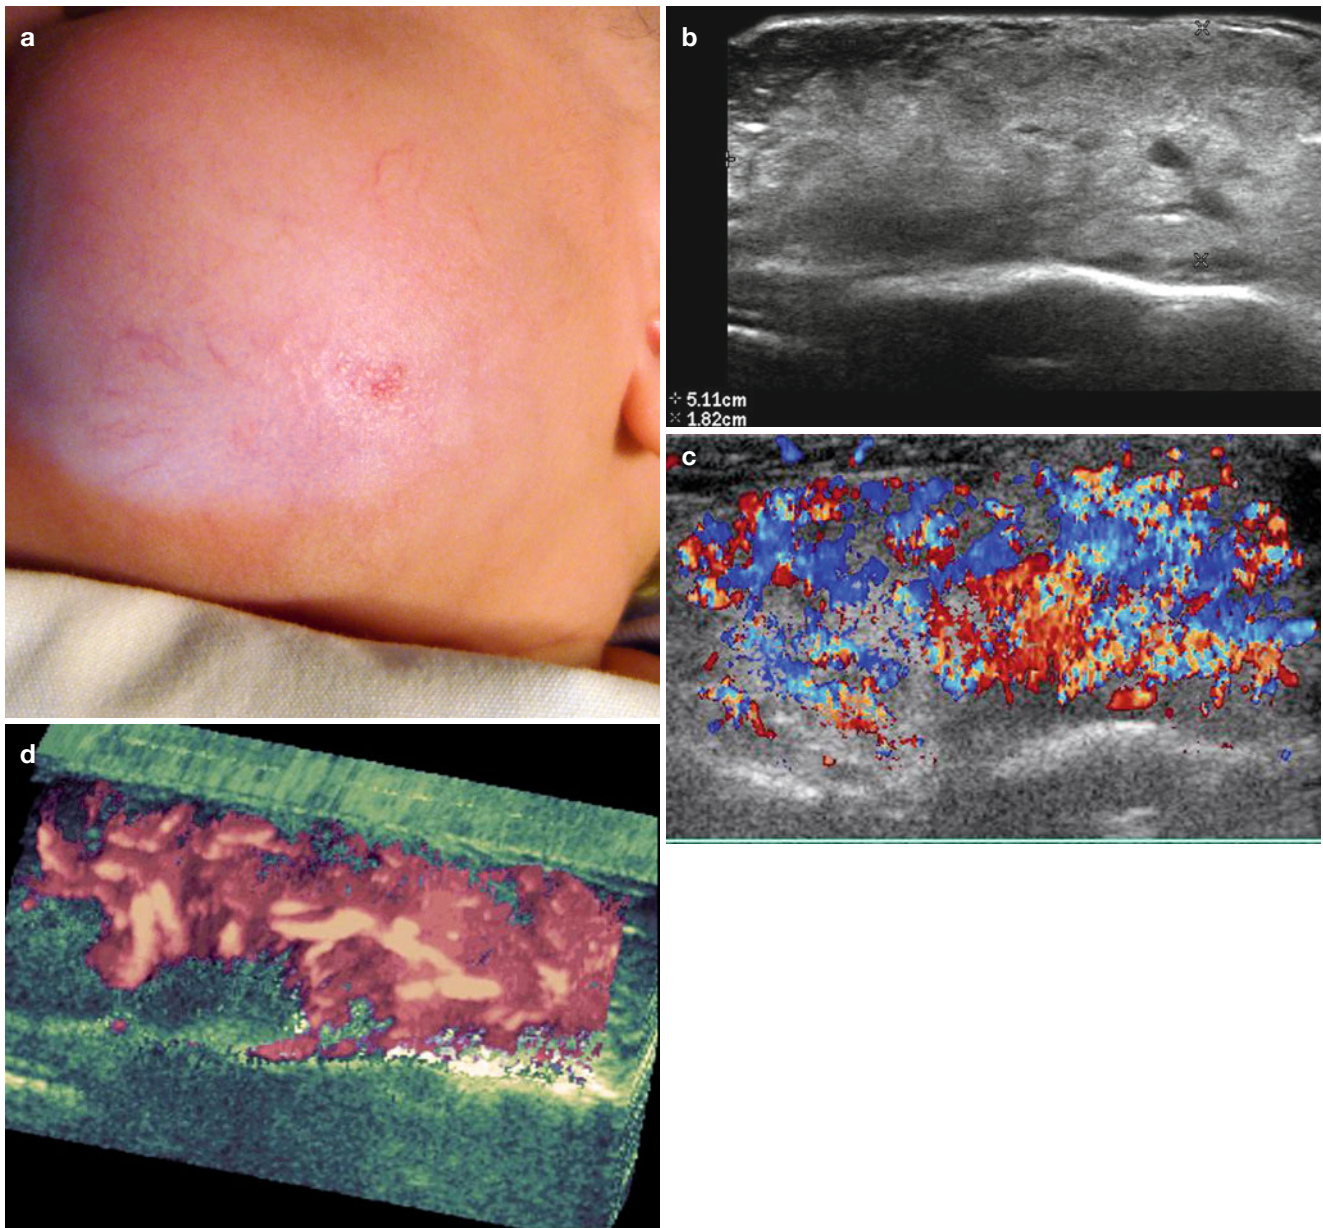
(a–d) Hemangioma (partial regression phase). (a) Clinical erythematous lesion in the left cheek. (b) Grey scale ultrasound image (transverse view) that shows 5.11 × 1.82 cm ill-defined heterogeneous mass that involves dermis, subcutaneous tissue and the masseter muscle.
